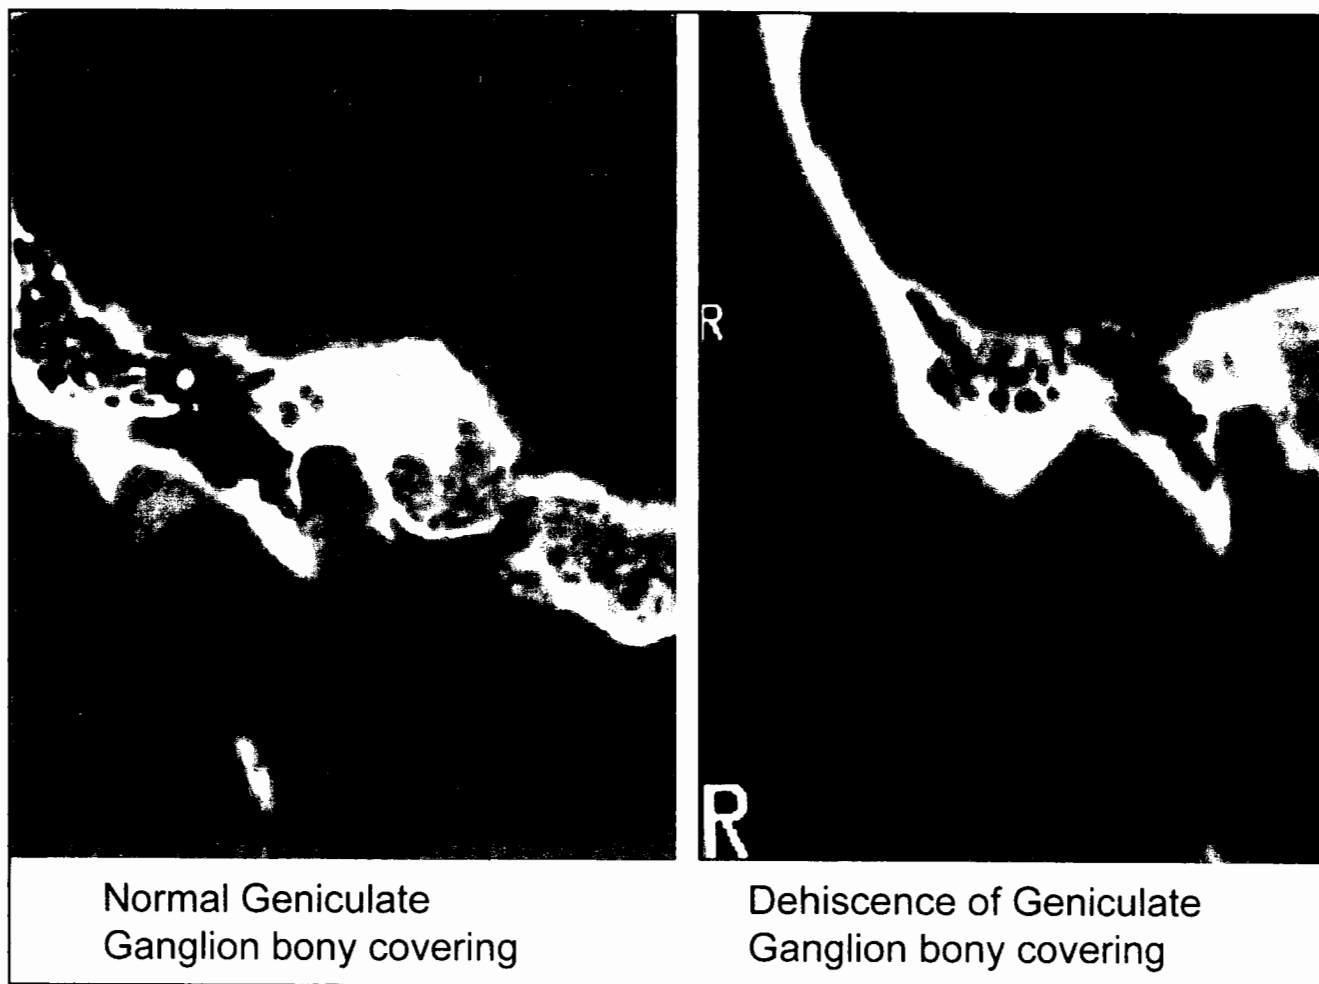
Coronal CT scans of normal bony covering of the geniculate ganglion in a non-SSCD patient (*left*) and a dehiscence of the geniculate ganglion in an SSCD patient (*right*).
